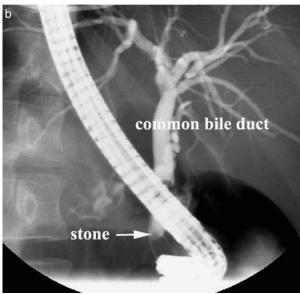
Small stone (diameter about 5 mm) at the distal common bile duct in ultrasound (US) (a) and endoscopic retrograde cholangiography (ERC) (b).
